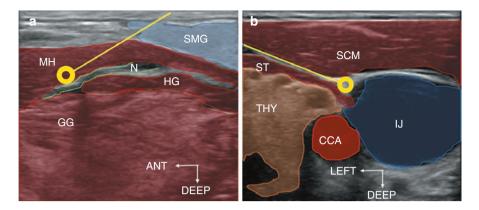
Ultrasound localization and percutaneous neurostimulation of (a). The hypoglossal nerve and (b) The branch of the ansa cervicalis to the sternothyroid muscle [70]. (a) Ultrasound image of right hypoglossal nerve in a parasagittal plane traversing between mylohyoid and hyoglossus muscles to distal insertion. EMG needle course in yellow. SMG submandibular gland, MH mylohyoid, HG hyoglossus, GG genioglossus, N hypoglossal nerve, ANT anterior. (b) Ultrasound localization of right sternothyroid muscle innervation by ansa cervicalis in the axial plane. Nerve is triangulated, not visualized. EMG needle in yellow. SCM sternocleidomastoid muscle, ST sternothyroid muscle, IJ internal jugular vein, CCA common carotid artery, THY thyroid gland
